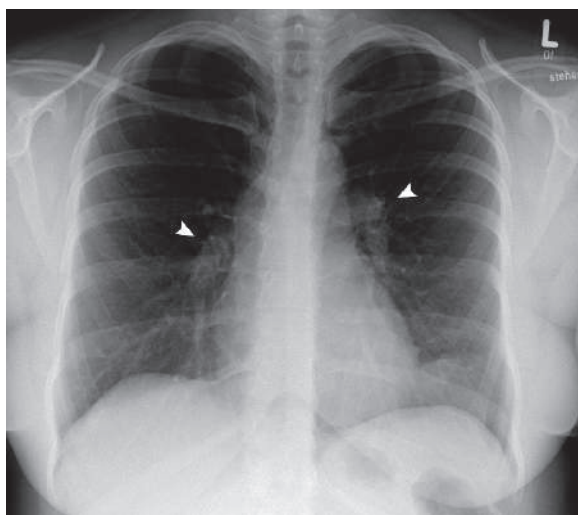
Posteroanterior chest radiograph of a female patient with grade 2 pulmonary sarcoidosis shows bilateral hilar lymphadenopathy (arrowheads) with clear lung fields
